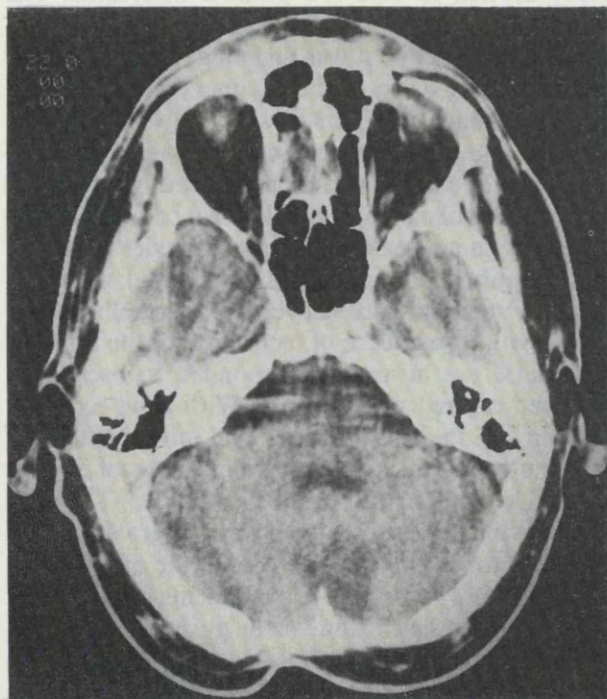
Patient B11526. High resolution CT scan showing a large CSF density space between the cerebellar hemispheres.
